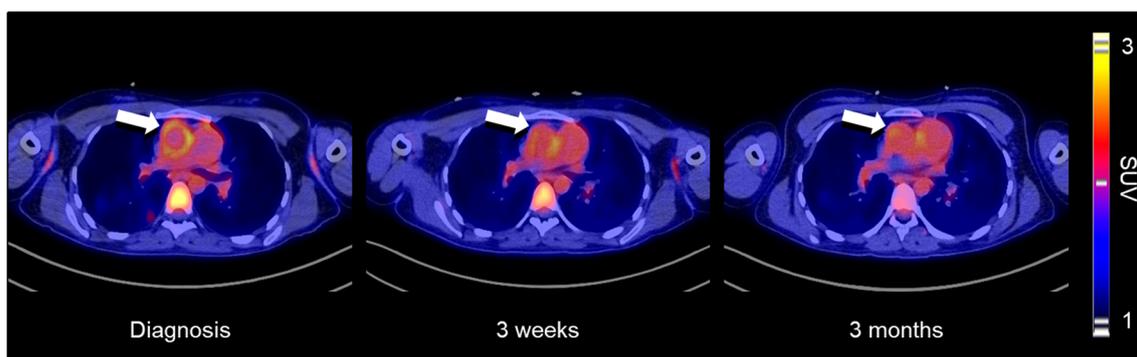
Selected axial FDG PET/CT images of a 26-year-old female with Takayasu's arteritis. The initial image obtained at time of diagnosis (left) shows increased circumferential FDG uptake in the wall of the ascending
